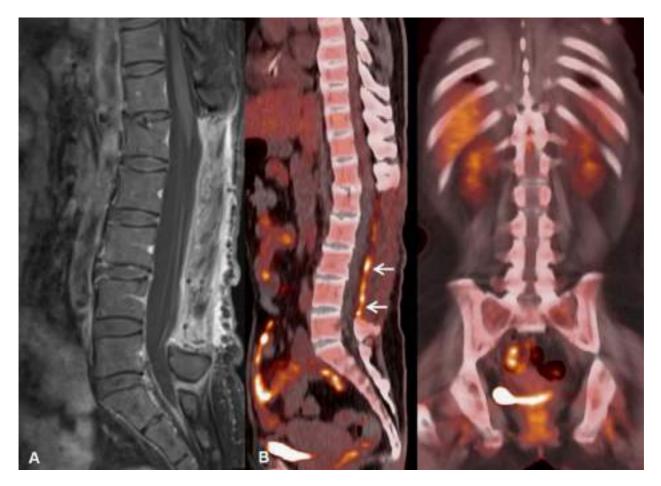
Follow up MRI (A) and PET-CT (B) after chemotherapy showing complete resolution of the hypermetabolic cauda equina lesion. Linear FDG uptake in the posterior lumbar dura (arrows) is postoperative in nature.
